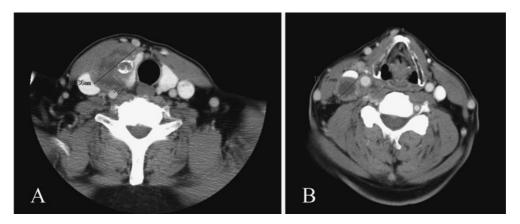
Initial enhanced cervical computed tomography findings. A: A 4.6×3.6 cm tumor with internal heterogeneity was observed arising from the right thyroid lobe.
